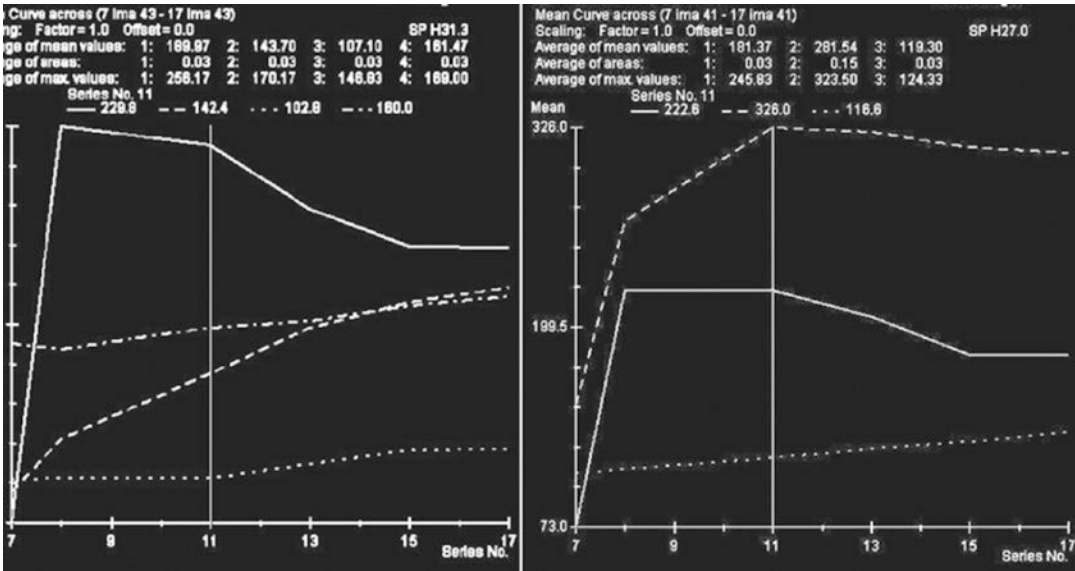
The same case: the specificity of MRI is low, and the contrast-enhancing curves are dependent on the subjective choice of the region of interest (ROI) and on the lesion size; for the smallest, the partial volume artifact is
